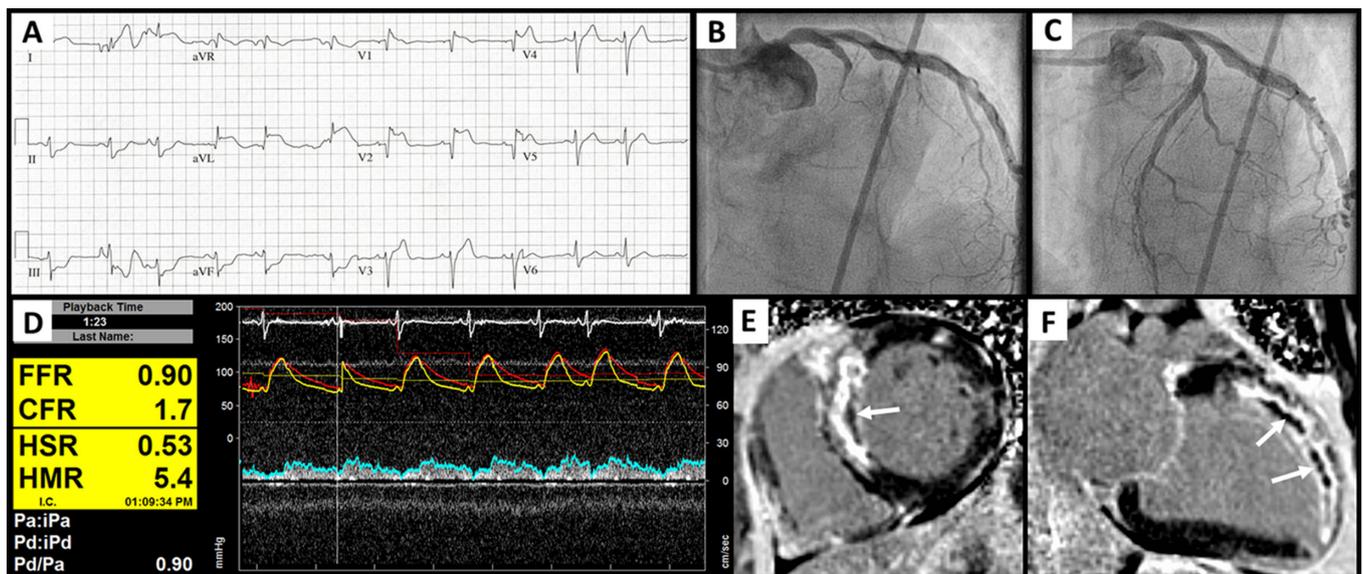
Patient with ST-elevation myocardial infarction enrolled into the study. This patient presented with acute chest pain for 180 min and ST-segment elevation in the anteroseptal leads, with reciprocal depression in the inferior leads (panel A). Emergency coronary angiography was performed showing a proximal left anterior descending artery occlusion (panel B). After primary percutaneous coronary intervention, thrombolysis in myocardial infarction III flow was restored (panel C). Simultaneous Doppler flow velocity and distal pressure measurements were performed in the distal left anterior descending artery (LAD) with intracoronary adenosine 150 µg, yielding a coronary flow reserve (CFR) of 1.7 and hyperaemic microvascular resistance (HMR) of 5.2 mm Hg·cm⁻¹·s (panel D). (Panels E and F) Cardiac MRI with late gadolinium enhancement showed a large area of hyperenhancement consistent with an anteroseptal infarction. Within this area, a hypo-enhanced core is visible consistent with extensive microvascular injury (indicated by arrows). Panel E is a short-axis view and panel F is a long-axis view. FFR, fractional flow reserve.
